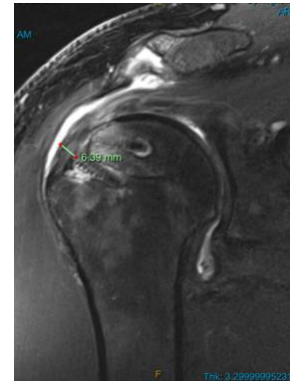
Tendon thickness measurement at the footprint near the repair site on T2-weighted coronal oblique sequence.
